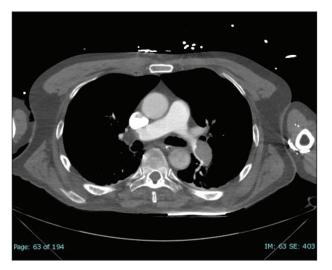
CTA showed occlusive thrombus burden in left and right PAs.
